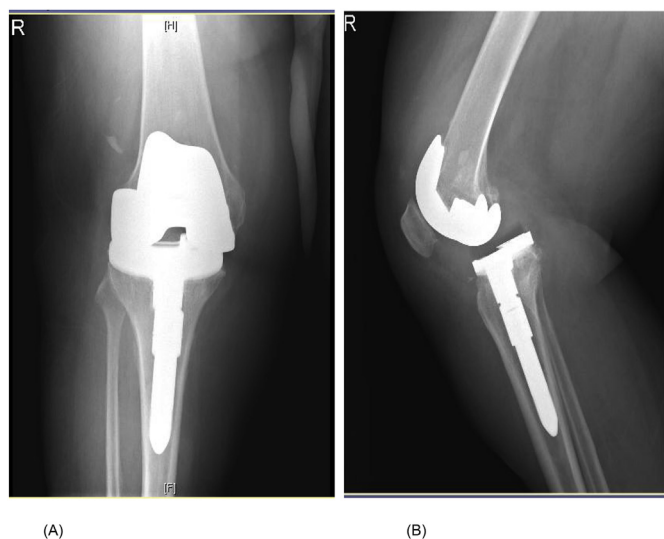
Anteroposterior (A) and lateral (B) radiographs showing dislocation and anterior displacement of the tibia on the femur of the right knee.
